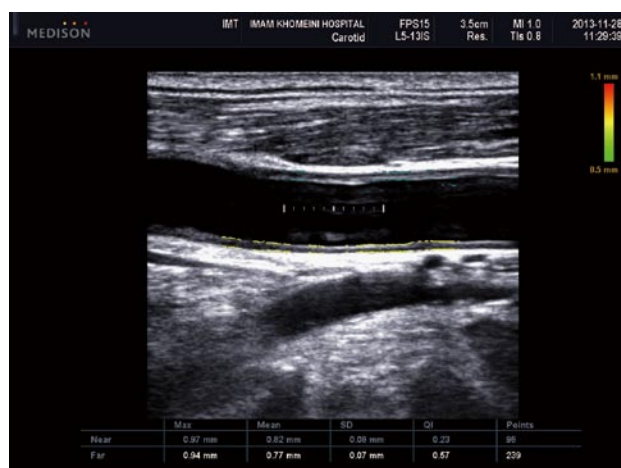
Ultrasonogram shows increased intima-media thickness of both near (0.82 mm) and far wall (0.77 mm) of common carotid artery in patients with ankylosing spondylitis.
